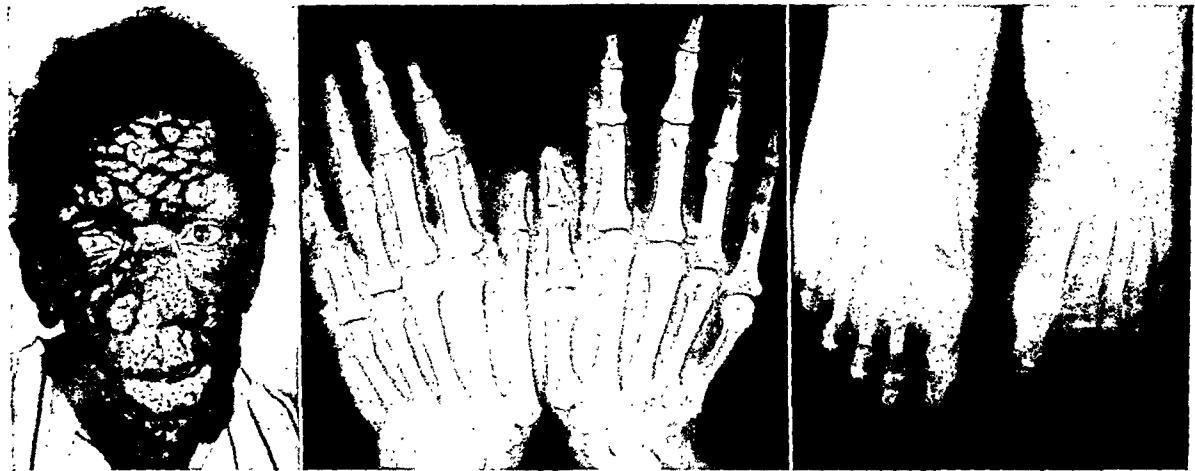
Lepromatous leprosy of fifteen years' duration in a colored female, American, 42 years of age, showing leonine facies, leprosy keratitis, and corneal opacities. Upper and lower limbs are also covered by extensive lepromatous nodulation and infiltration. There is no x-ray evidence of bone changes in hands or feet, the usual observation in lepromatous cases.
